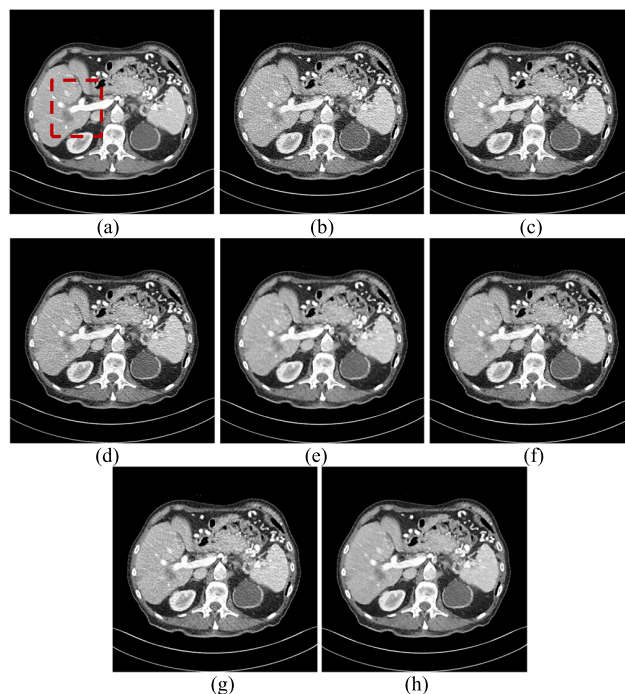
Results of an abdominal CT scan from the testing set using different methods. (a) Normal dose, (b) Low dose, (c) NLM, (d) BM3D, (e) RED-CNN, (f) WGAN-VGG, (g) SMGAN, (h) Proposed.
